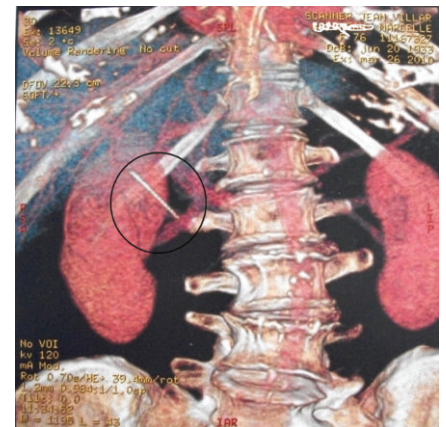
3D abdominal computed tomography scan reconstruction showing the straight, hyperdense image of about 3.5 cm in length in the right hypochondrium (encircled).
